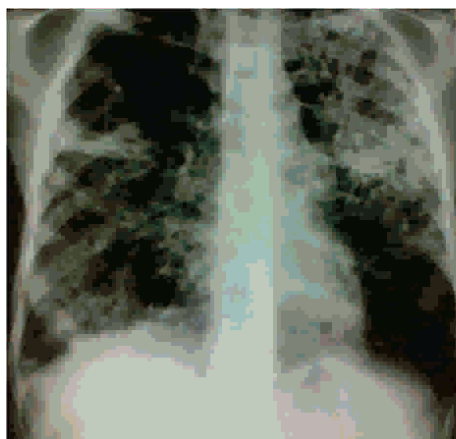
Chest X-ray, Extensive and Bilateral Excavated lung Lesions in COPD
